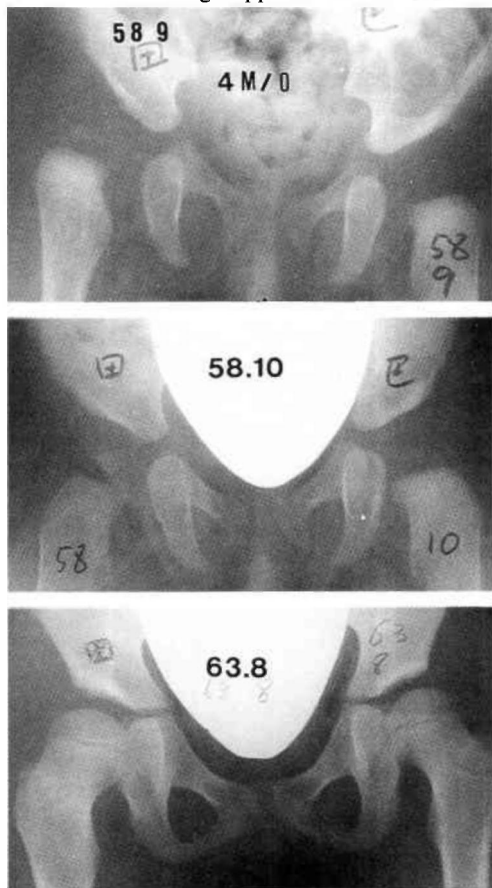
(Top) Series 1 T.T. a 4 month old female diagnosed as Grade 3 dislocation. Pavlik harness was applied on 14 September 1983. Two weeks later reduction was still not obtained. On 27 September, knee splint was applied to the right knee. Three days later, reduction appeared to have been achieved but dislocation still occurred when the hip was adducted. The roentgenogram was taken on 14 September 1983 prior to application of the harness.
